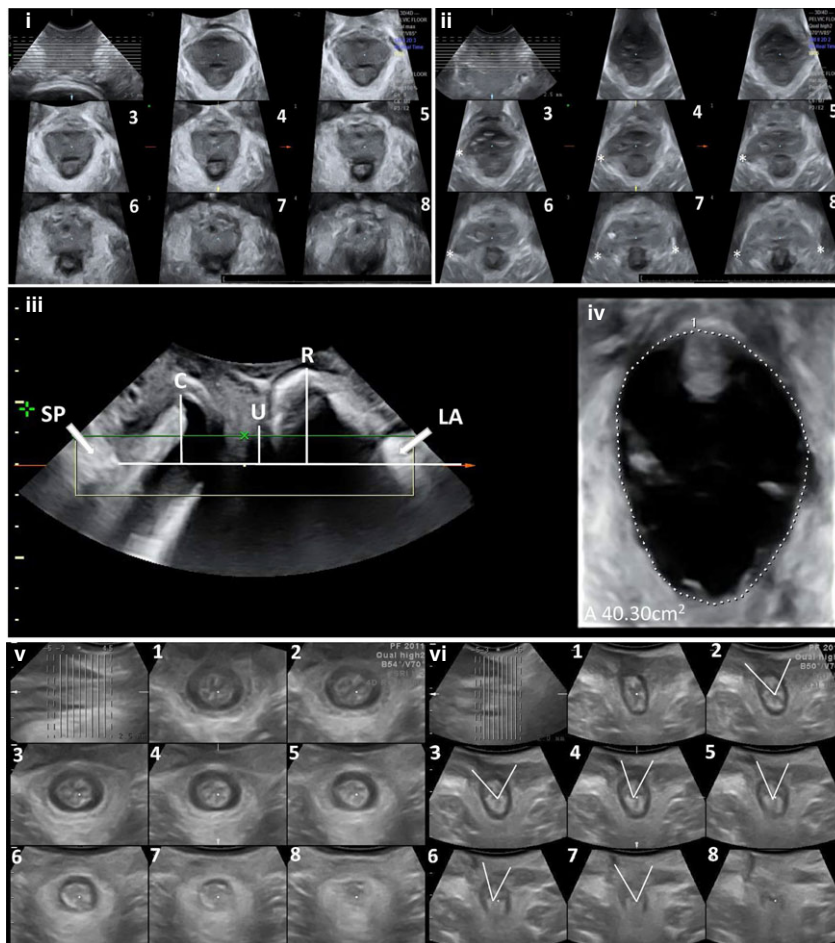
Tomographic ultrasound imaging (TUI): (i) normal pelvic floor; (ii) a right-sided levator avulsion, marked with *, in slices 3–8, and a left-sided partial avulsion in slices 7 and 8; (iii) measurement of pelvic organ descent against a reference line placed through the symphysis pubis (SP); C, cystocele; LA, levator ani; R, descent of the rectal ampulla; U, uterine descent; (iv) determination of levator hiatal area on maximal Valsalva in the axial plane of minimal hiatal dimensions; (v) intact/normal EAS; (vi) significant residual defect of the EAS. Angled lines show defect location and size.
